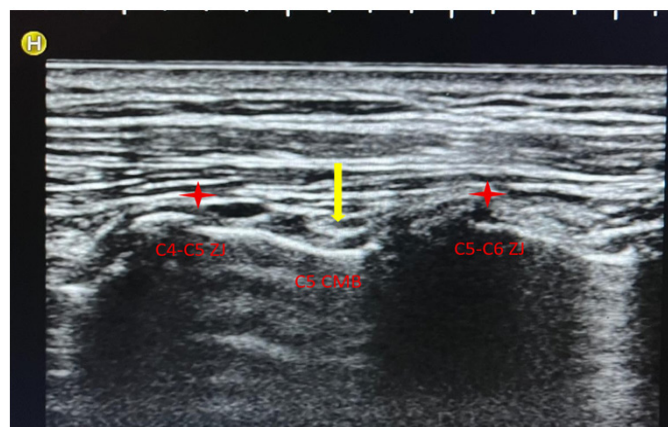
Sonographic localization of the C5 cervical medial branch in the sagittal plane
